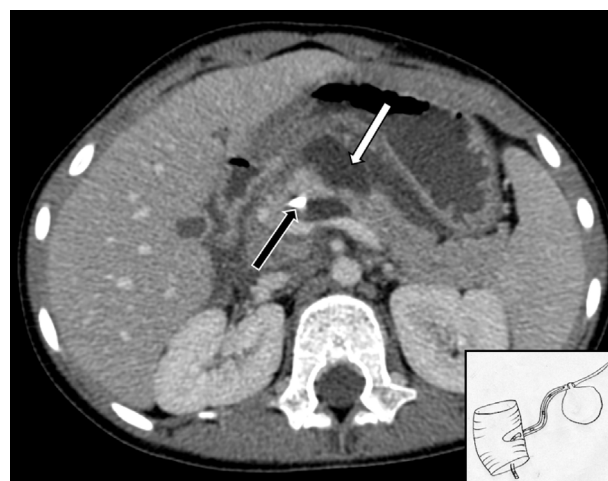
Abdominal CT scan (axial slice) showing the pseudo-cyst (white arrow) secondary to stent migration (black arrow).
